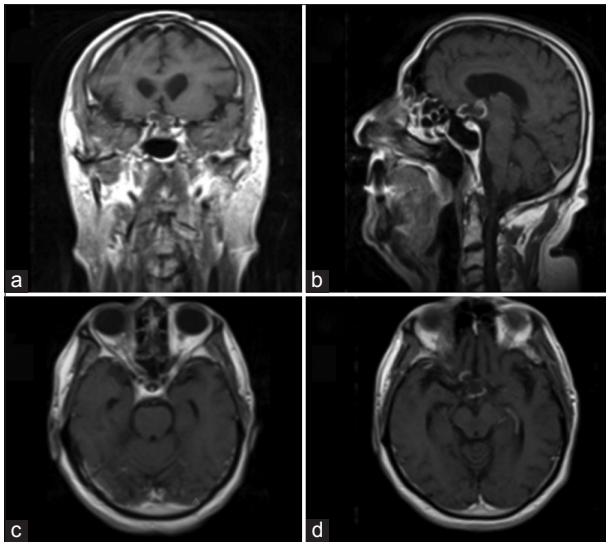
(Case 6) Magnetic resonance imaging in coronal (a), sagittal (b), and axial (c and d) T1 fat saturated post-contrast planes, showing progression with enhancement of retrobulbar and prechiasmatic optic nerves bilaterally more on the right
